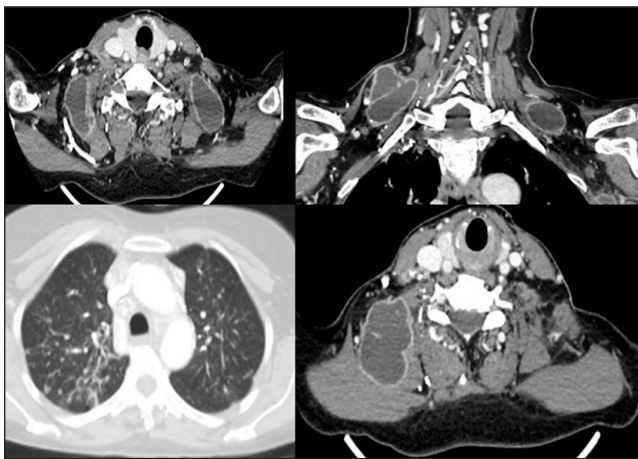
Axial CT scans of the neck and chest at various levels, demonstrating extensive tuberculous cervical soft tissue and abscessed lymphadenopathy, as well as bilateral pulmonary infiltrates.
